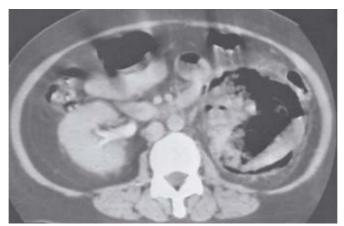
Enhanced axial CT image of the kidneys.
